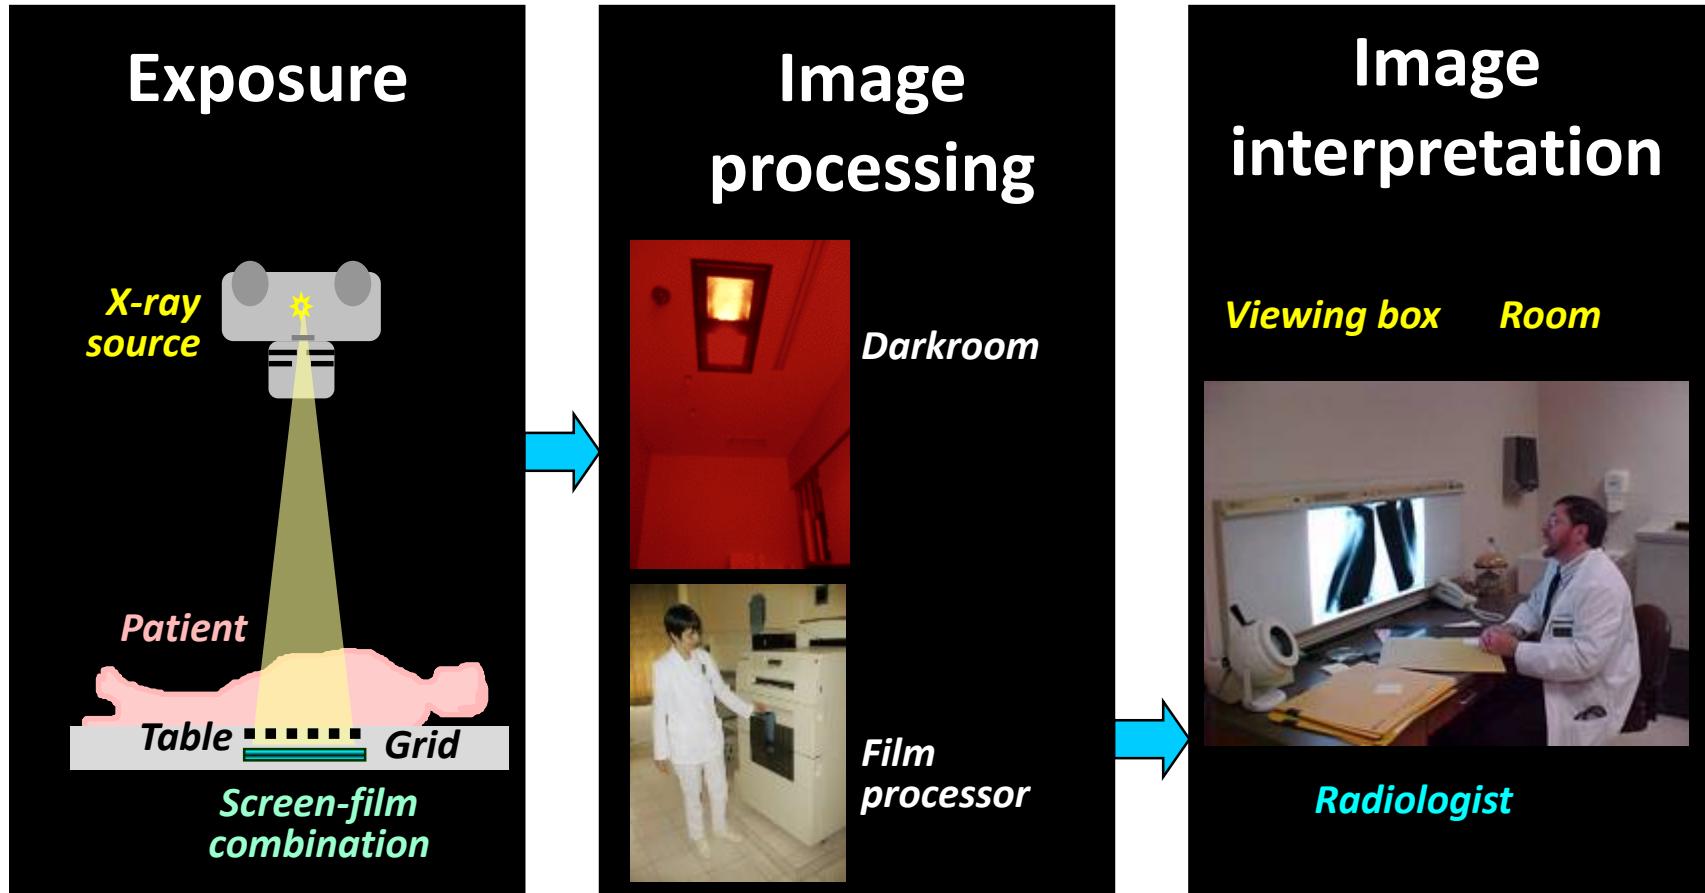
Image formation in radiography
